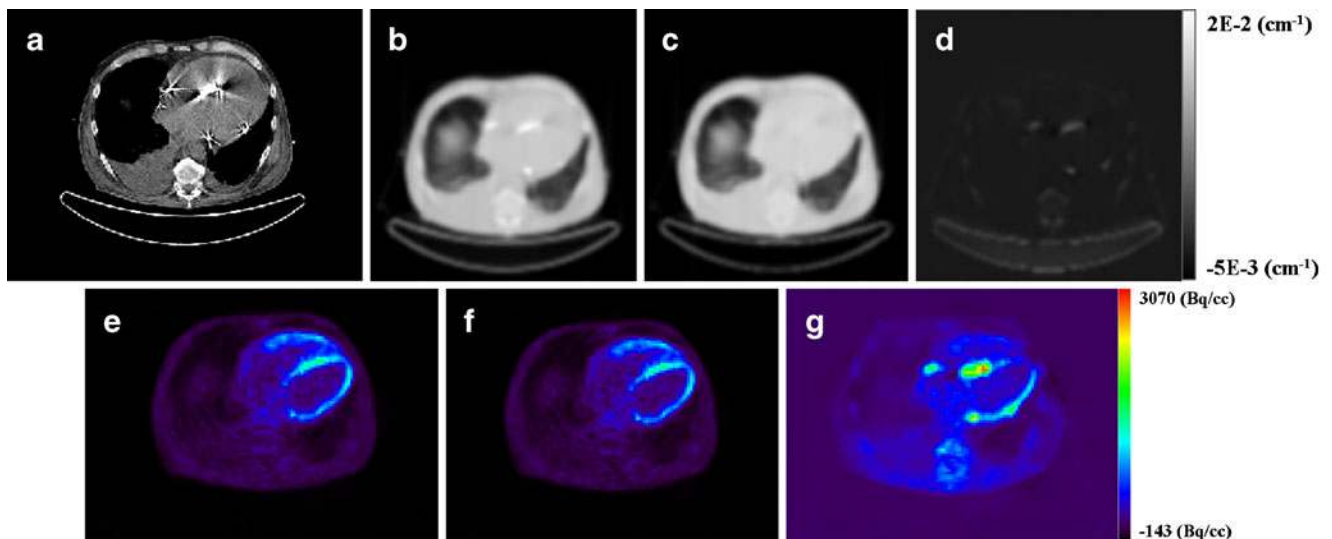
Typical transverse slice in a patient with a pacemaker lead: a original CT image, b  $\mu$ -map generated without MAR, c  $\mu$ -map generated with MAR, d difference image between  $\mu$ -maps, e PET image reconstructed without MAR, f PET image reconstructed with MAR, g difference between PET images
